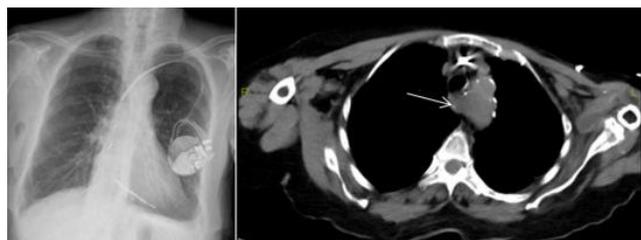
The patient’s PA AC was unremarkable. A non-contrast thorax CT scan revealed an aberrant subclavian artery (white arrow), giving the impression of a mediastinal mass
